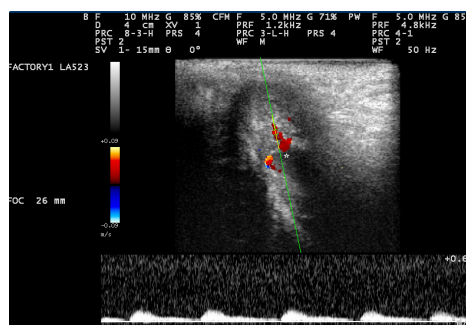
Four weeks after angiography, at Doppler sonography, peak systolic velocity is decreased but continuous diastolic flow is also detected.
